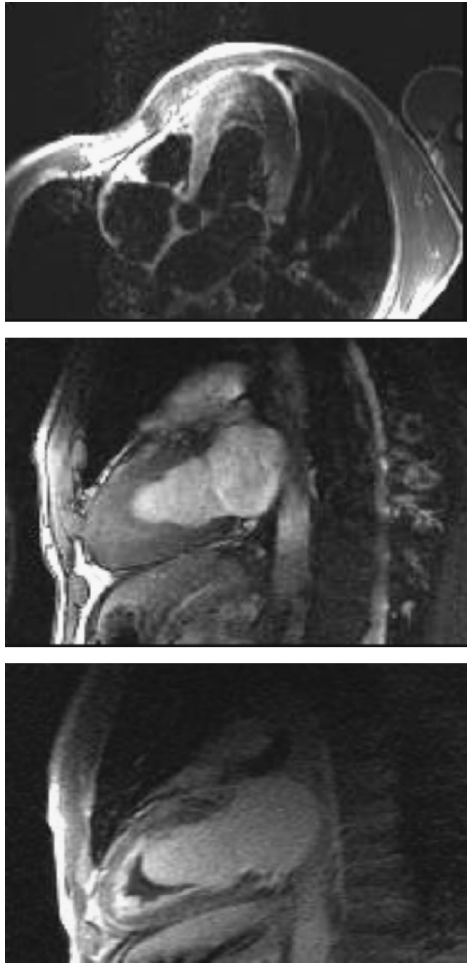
MRI findings. Upper panel: spin echo image in horizontal long axis. Middle panel: Cine FIESTA image in vertical long axis. Lower panel: image obtained with a delayed enhanced sequence after injection of gadolinium-based contrast agent. The apical wall is thickened by the presence of fibronectic material (showing an enhanced pattern) and by thrombotic material (showing a hypo-intense pattern).
